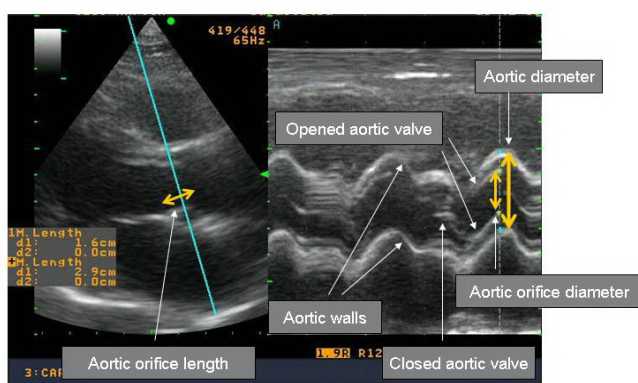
M mode examination of the aortic valve in parasternal long-axis view
